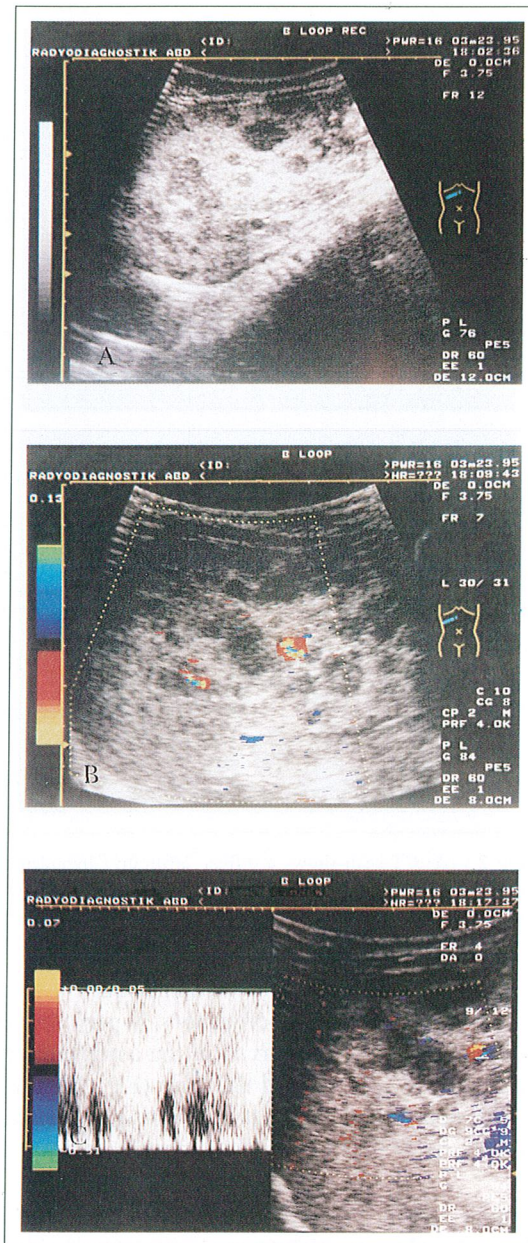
(A) US image shows multiple clearly defined hypoechoic lesions of about 1-2 cm in diameter in both lobes of the liver. Some of the lesions tend to join together. (B) Color Doppler US image shows several tangled masses of vessels around hypoechoic lesions. (C) Duplex Doppler image reveals arteriovenous shunting with a spectrally broadened, mixed arterial and venous, high-amplitude pattern in the vascular lesion located in the right lobe of the liver.
